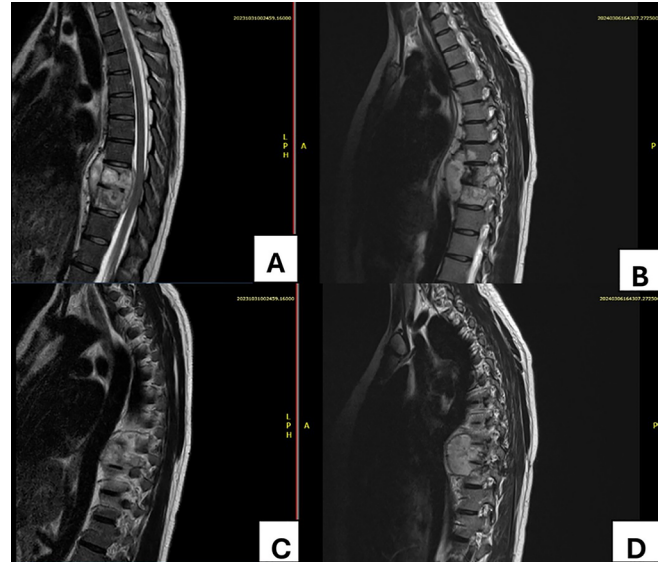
Longitudinal T2-weighted MRI slices of the thoracic spine. A and C: Before the start of tuberculosis treatment, showing spondylodiscitis with a fluid collection adjacent to the T9 and T10 vertebral bodies, deforming the dural sac, and suggesting signs of incipient myelopathy. B and D: After 3 months of treatment, there was an increase in the fluid collection with a change in the spinal cord signal, characterizing compressive myelopathy.
